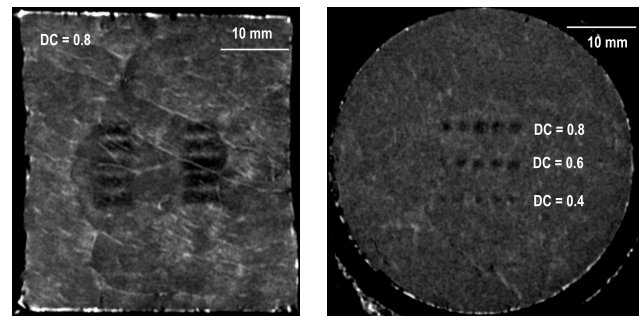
T1-weighted MR images of axial (left) and radial (right) – in the focal plane – sections of lesions formed inside the tissue sample by 5 HIFU beams with a frequency of 3.21 MHz, pulse duration of 0.3 s, and duty-cycle varied: 0.4 (bottom); 0.6 (middle) and 0.8 (top).
